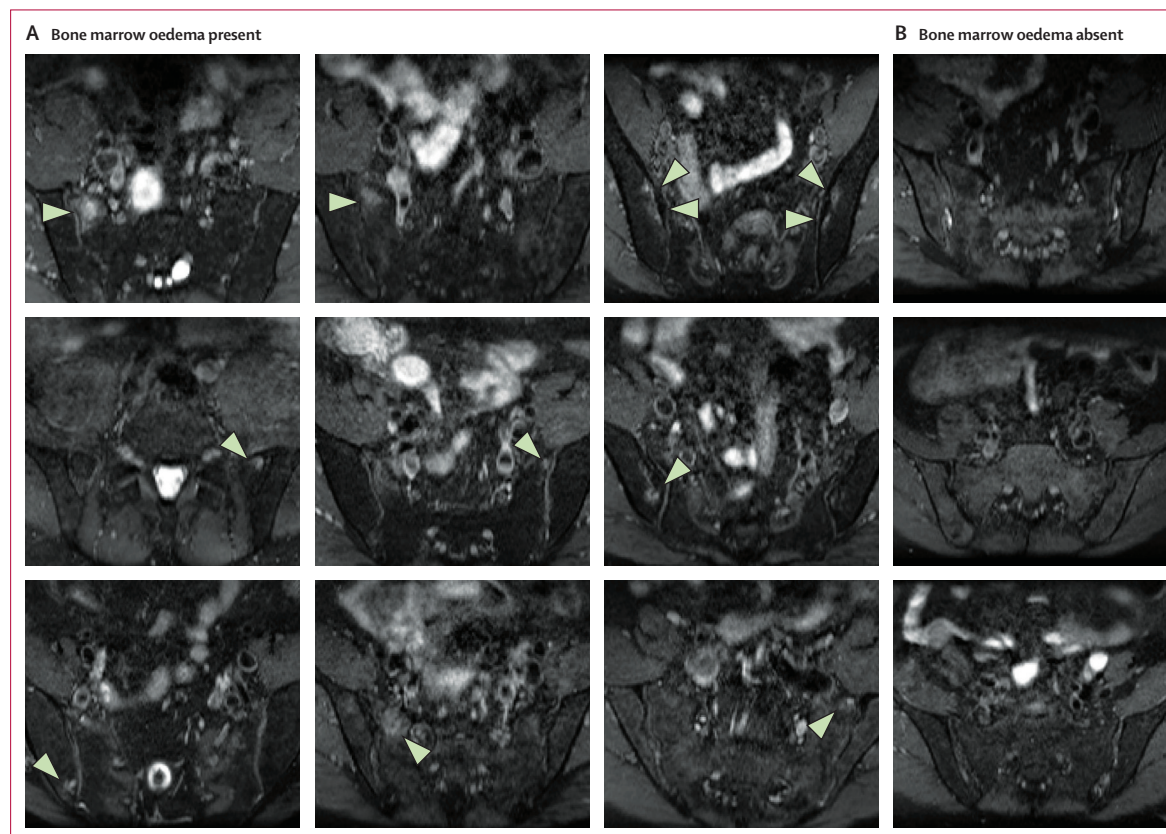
Examples of bone marrow oedema on pelvic MRI
